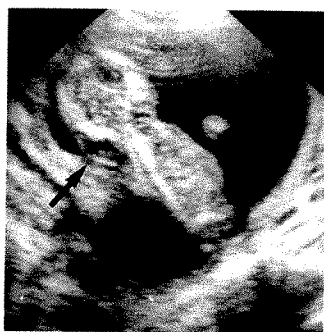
Sonogram shows non-septated nuchal cystic hygroma (arrow) in a 14-week-old fetus.
